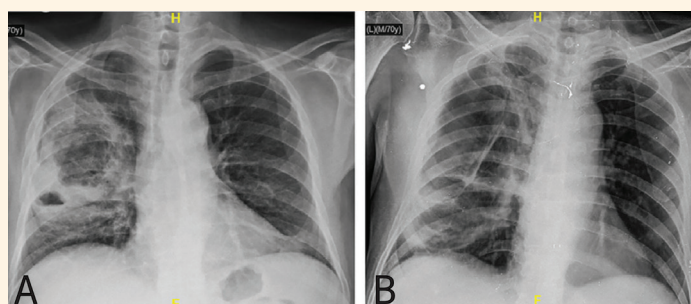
Chest X-ray of a mixed infection of *Aspergillus* and *Mucor* showing significant radiological resolution after three weeks of amphotericin B therapy in a 65-year-old male patient.
